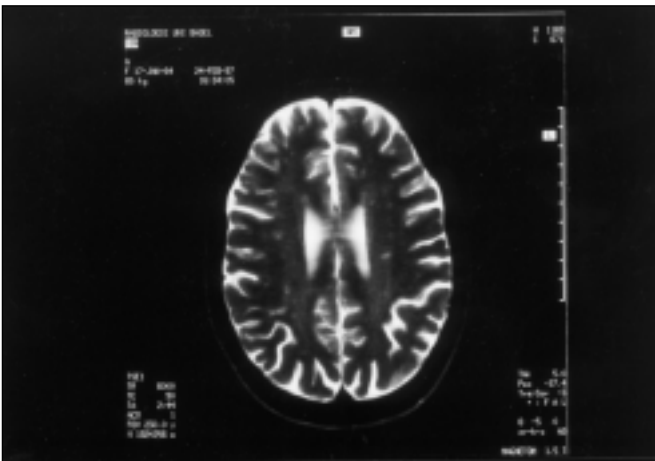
MRI (1997) of the brain showing multiple hyperintensive spots in both hemispheres in a T2 weighted image.
